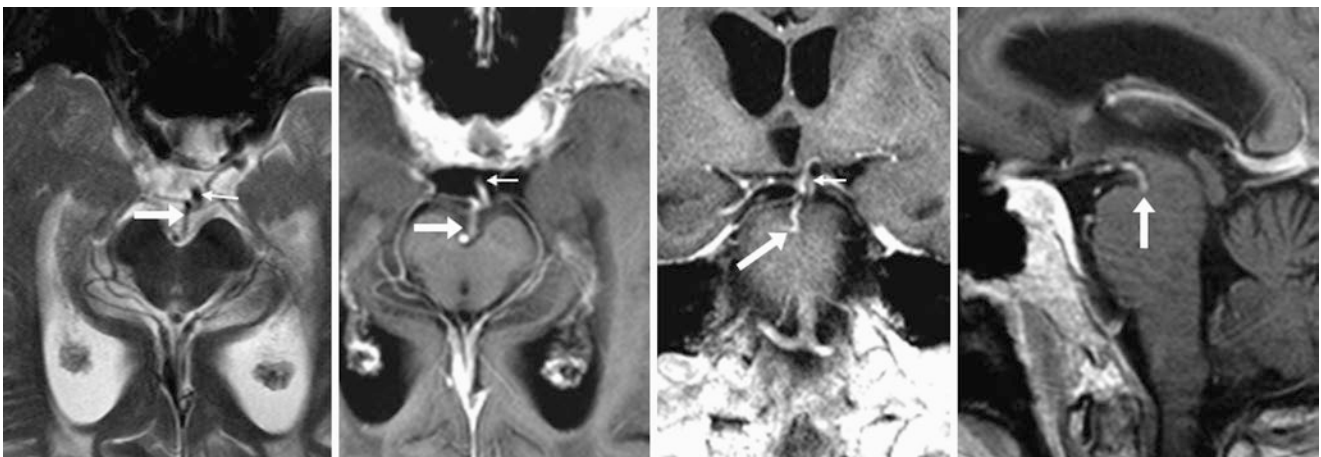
77-year-old with an APMV (arrows) within the interpeduncular fossa. The APMV appears inseparable from the basilar artery (thin arrows) on axial T2WI MRI (left). Postcontrast T1WIs in axial (left
